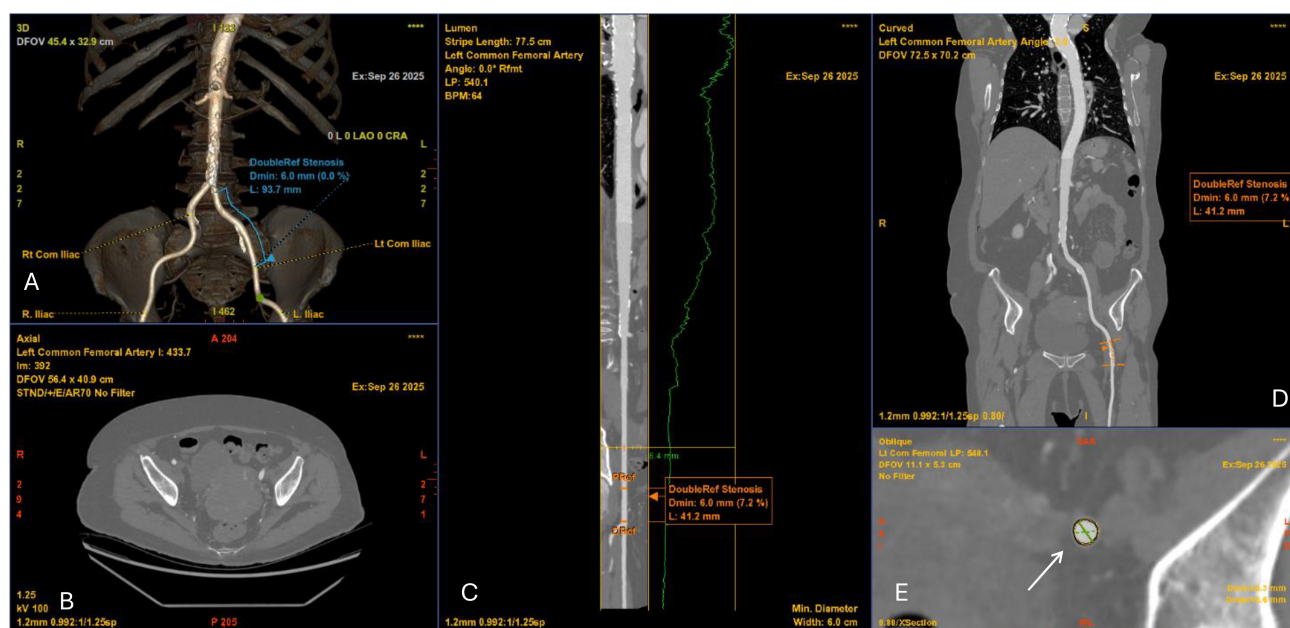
Computed tomography angiography (CTA) of the iliofemoral vessels for TAVI access planning. (A) 3D volume-rendered reconstruction of the iliofemoral arteries demonstrating vascular course and minimal luminal diameter of 6.0 mm. (B) Axial CTA slice at the pelvic level showing vessel lumen and surrounding structures. (C) Curved multiplanar reconstruction of the left common femoral artery with luminal profile (green line) demonstrating focal stenosis (minimal diameter 6.0 mm). (D) Coronal CTA reconstruction confirming the level of stenosis (6.0 mm). (E) Cross-sectional image at the site of stenosis (white arrow) with measurement of the minimal luminal area, relevant for determining vascular access feasibility.
